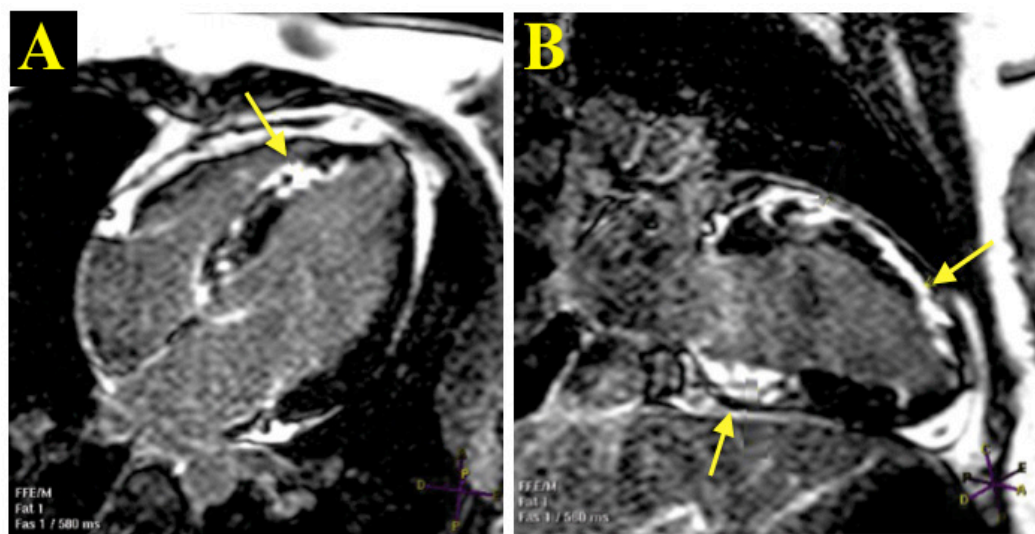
Magnetic resonance imaging showing transmural late gadolinium enhancement (arrows) of the inferior medium-basal, anterior and anterior-septal walls of the left ventricle in four-chamber (A) and two-chamber views (B).
